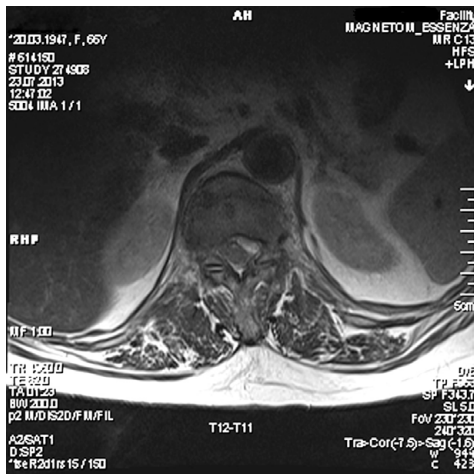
Axial T1 weighted MRI of the same case.
